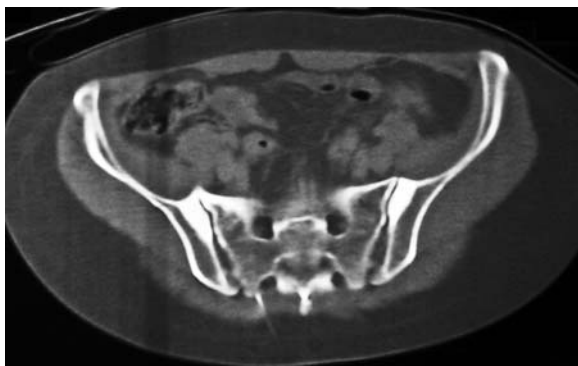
Non-enhanced axial CT image of a 37-year-old woman reveals bilateral osteitis condensans ilii and an anterior bridging osteophyte at the right sacroiliac joint
